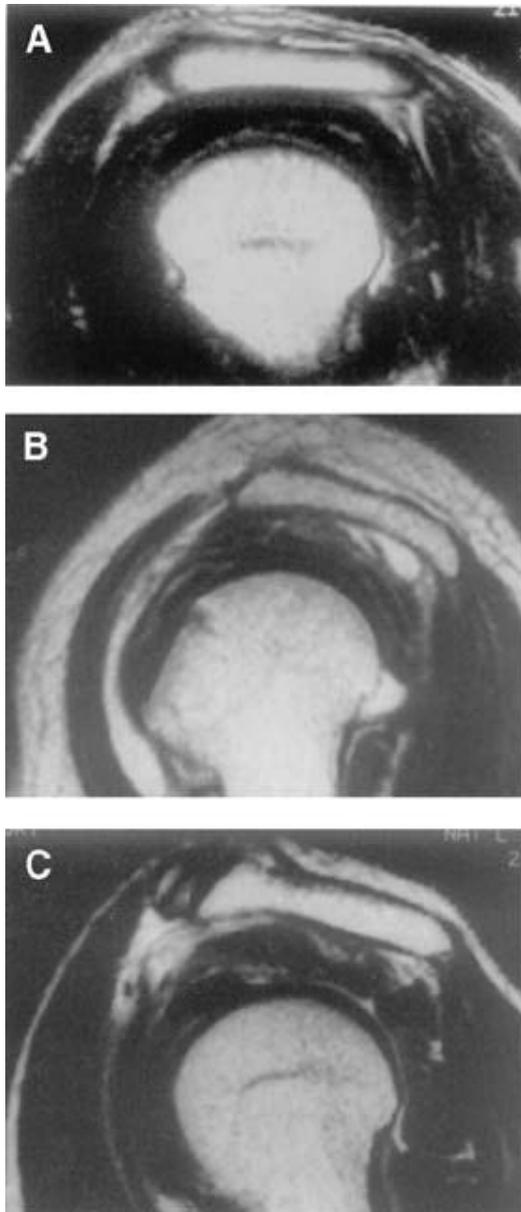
Acromial shapes determined by the sagittal oblique plane on MRI: type I (flat) (A), type II (curved) (B), and type III (hooked) (C). The longest dimension of the acromion was used to assess type²⁰
